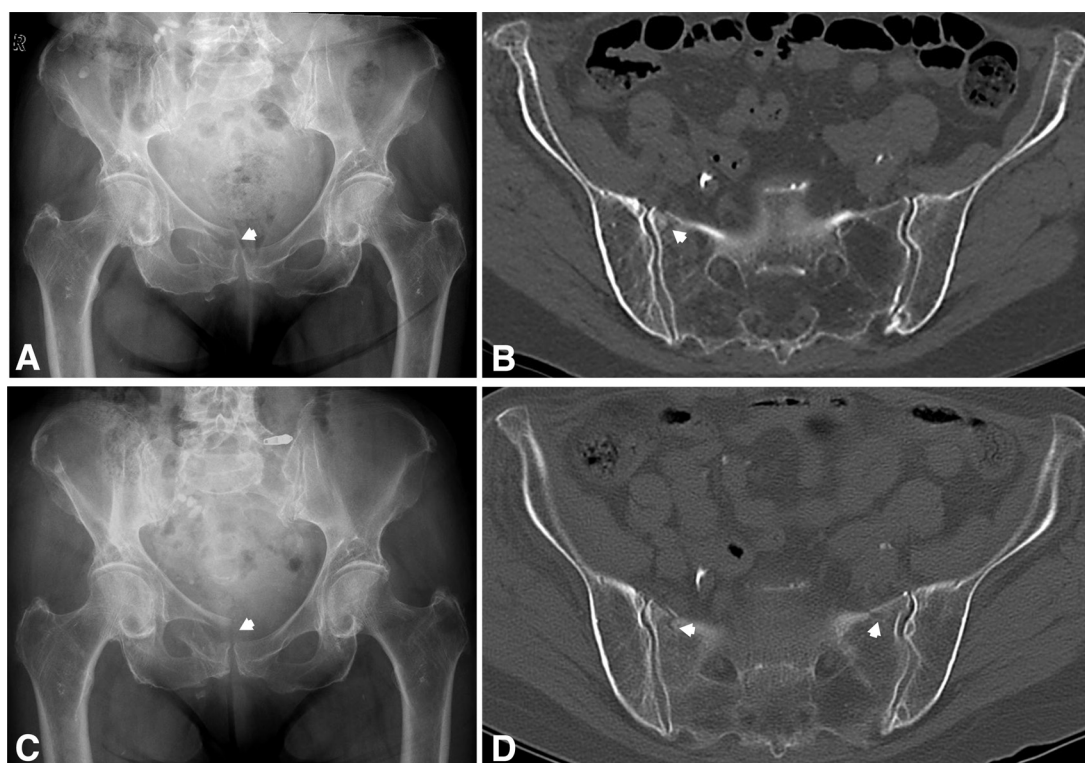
Patient presenting with severe low back pain and groin pain after a fall from a standing position. Conventional a.p. (A), inlet, and outlet radiographs revealed a displaced fracture of the anterior pelvic ring. The CT-scan showed a very thin fracture line in the sacral ala on the right site (B). During the next three weeks the patient was not able to bear weight due to therapy-resistant low back pain. Conventional X-rays showed a slight increase of fracture displacement of the anterior part of the pelvis (C), and bilateral fracture lines in the sacral ala become obvious (D).
